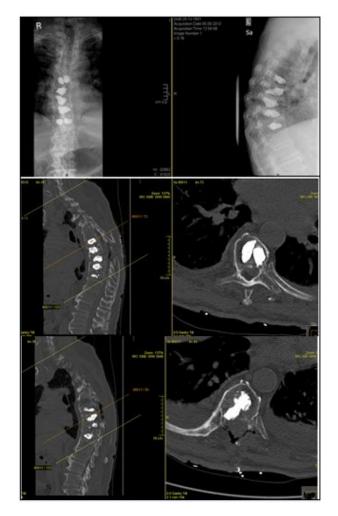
Clinical case No. 2 Postoperativelly X-Ray and CT. Surgical treatment:
